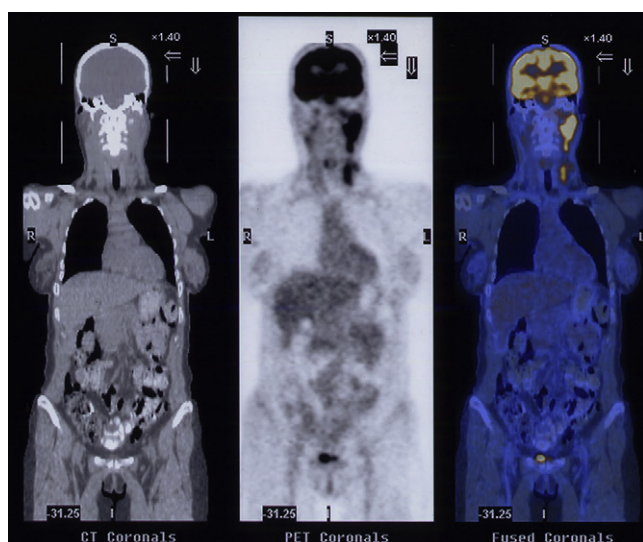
Diagnostic PET-CT with an increasing of tracer uptake of 18F-FDG in left nasopharynx and cervical lymph nodes.
